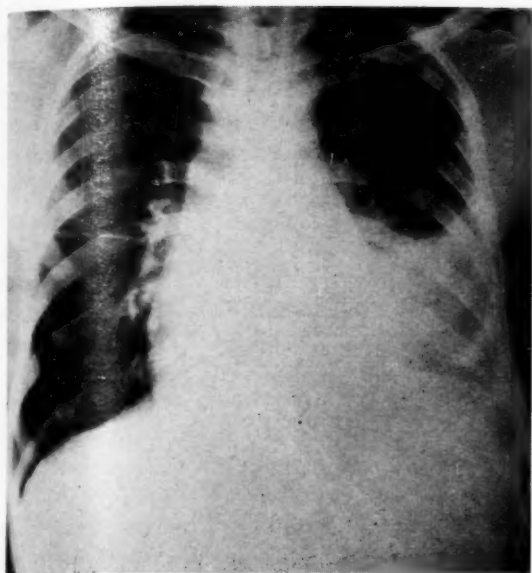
Posteroanterior roentgenogram of chest taken at first admission.
